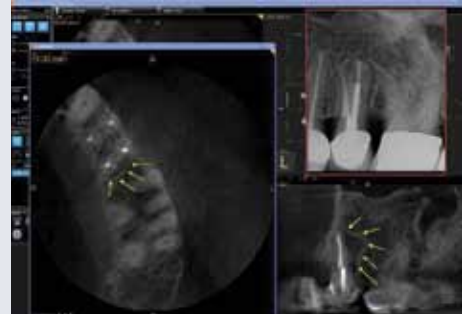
The 3D nature of cbCT scans allows visualizing the fracture line from multiple angles and different orientations at very thin slices and at a very high contrast.
